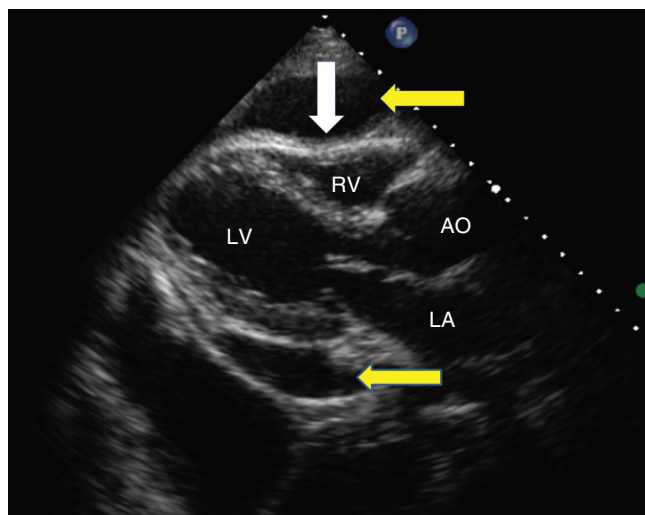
■ Two-dimensional echocardiogram (parasternal long-axis view) showing pericardial effusion (yellow arrows) and cardiac tamponade with collapse of the right ventricle (RV) at end-diastole (white arrow). AO, Aorta; LA, left atrium; LV, left ventricle.
